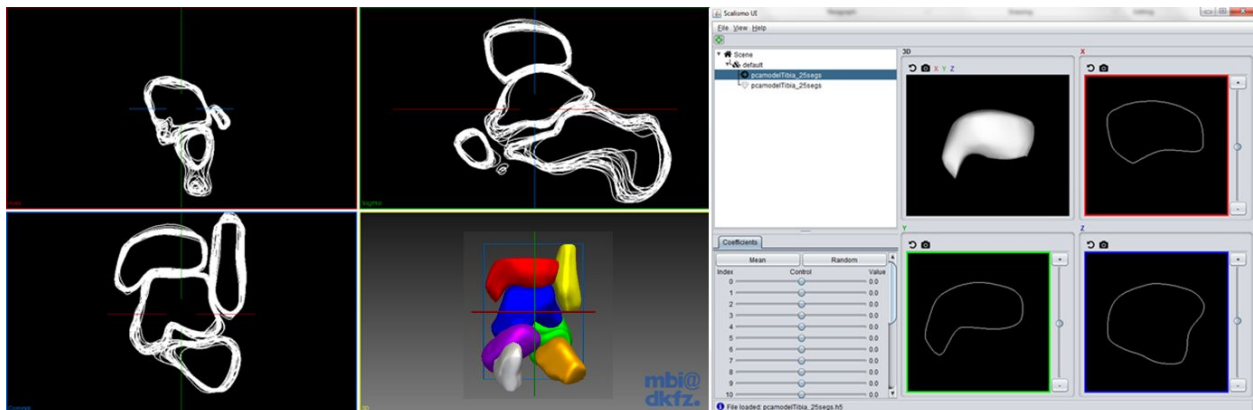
Example of multiple registered 3D CT segmentations of ankle bones (left) which are used to construct ASM (right).
